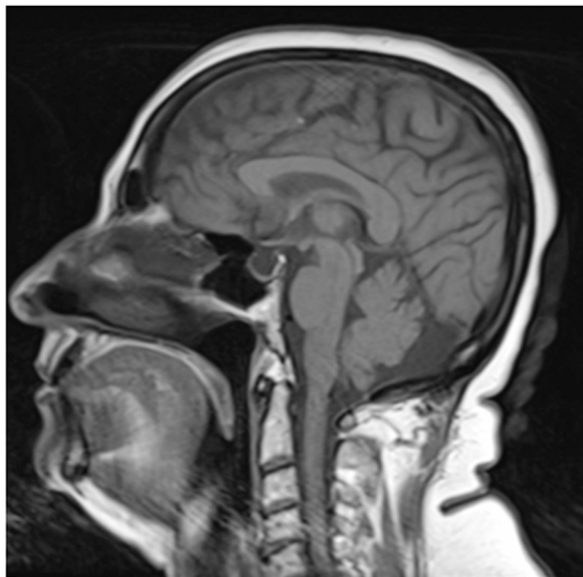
MRI-Brain of patient showing Empty Sella
